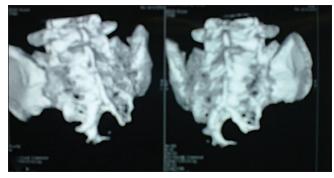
Reconstructed 3D CT shows the scimitar defect more clearly.
